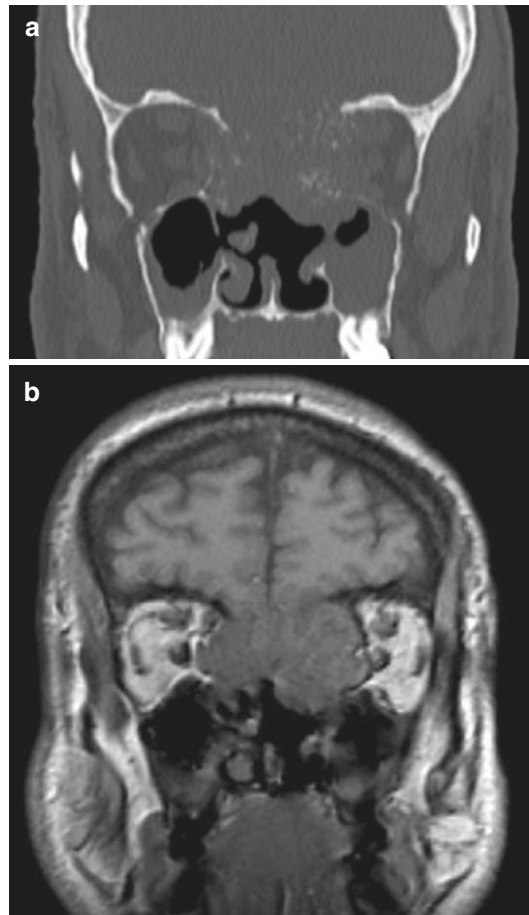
CT sinus scan showing calcified densities
